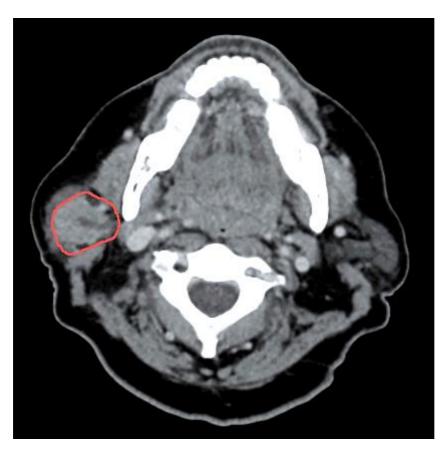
Pre-operative CT axial image at the level of the cervical level II region
